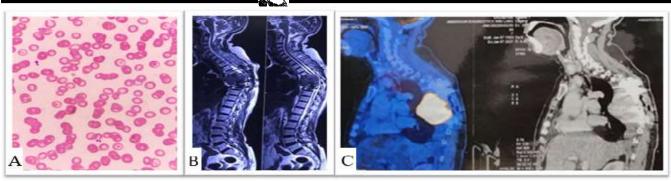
(A) Peripheral smear showing predominantly microcytic hypochromic RBCs with increased rouleaux formation. (B) MRI with contrast showing a hetero-intense soft tissue lesion causing destruction of D4,D5,D6 vertebrae. (C) PET CT showing a soft tissue mass causing destruction of the mid dorsal vertebrae.
